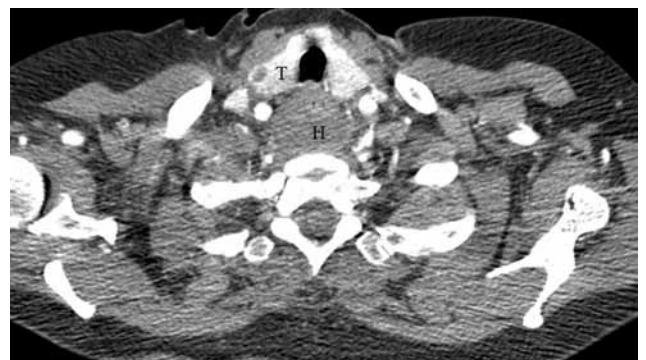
Postoperative control computed tomography angiography demonstrating that the reduced hematoma. The aneurysm is no longer visible. T: Thyroid; H: Hematoma.
